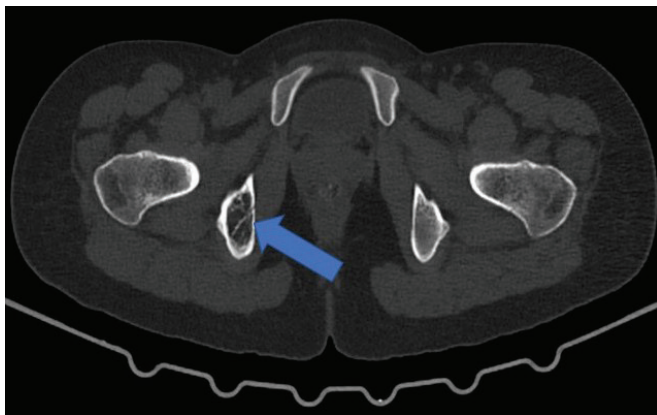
Axial CT image of the pelvis showing a well-defined mildly expansile lesion with fat density and multiple trabeculations in the right ischium (arrow). No calcifications or cortical destruction are noted.
